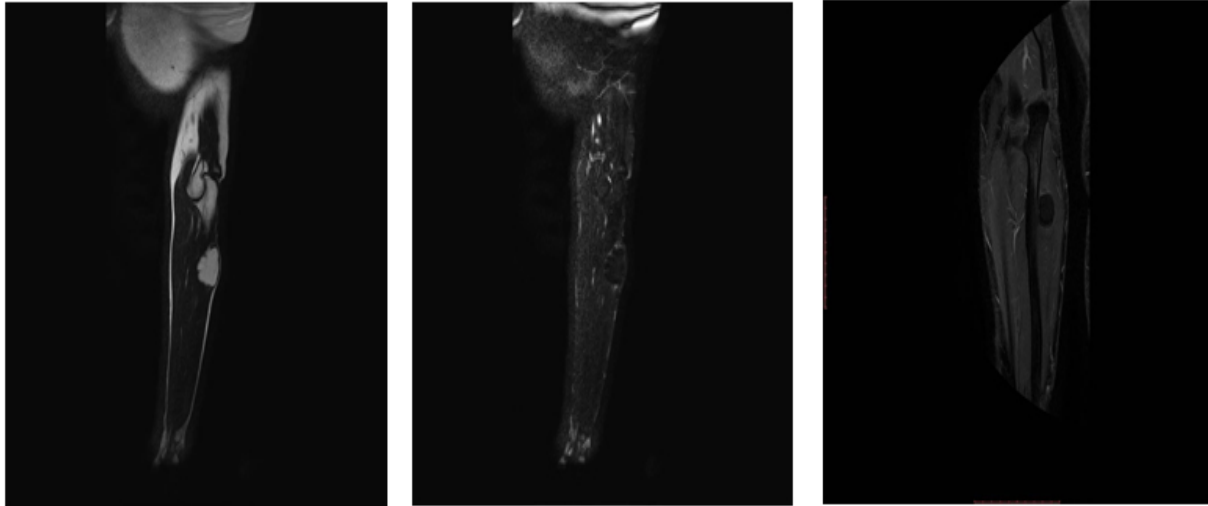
MRI sagittal (a) T2W, (b) T2W fat suppressed and (c) T1W post contrast fat suppressed shows the lesion flushed against the ulna with homogeneous loss of signal on fat suppression images. No muscle or bone marrow involvement is seen.
